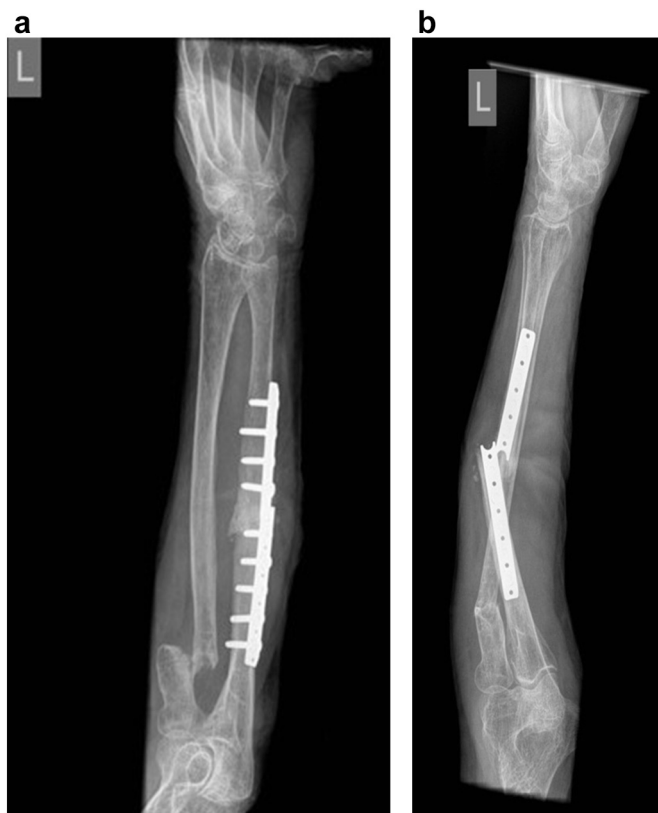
A-B: Radiographs showing breakage of ulna plate.
